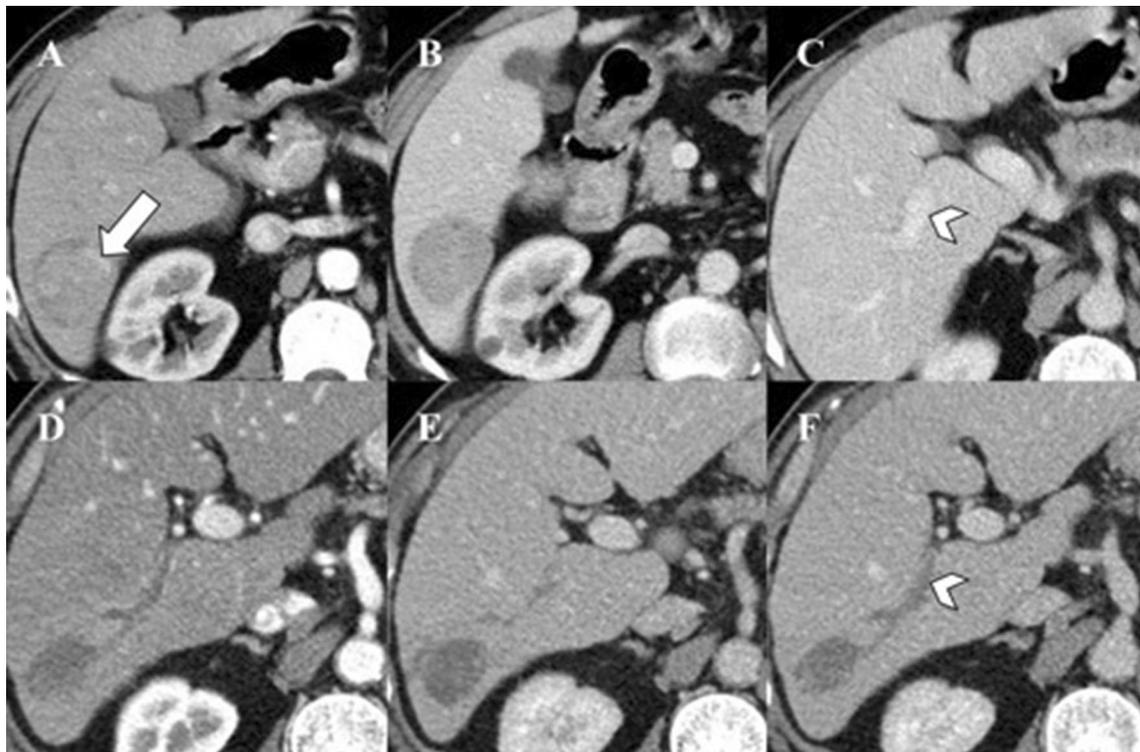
56-year-old man with HCV cirrhosis. Baseline contrast-enhanced CT (upper row) shows a 4.3 cm lesion with arterial phase hyperenhancement (a, arrow) and washout on portal-venous phase (b). Note a patent right portal vein (c, arrowhead). At six-month CT follow-up (bottom row), without interval treatment, demonstrates
